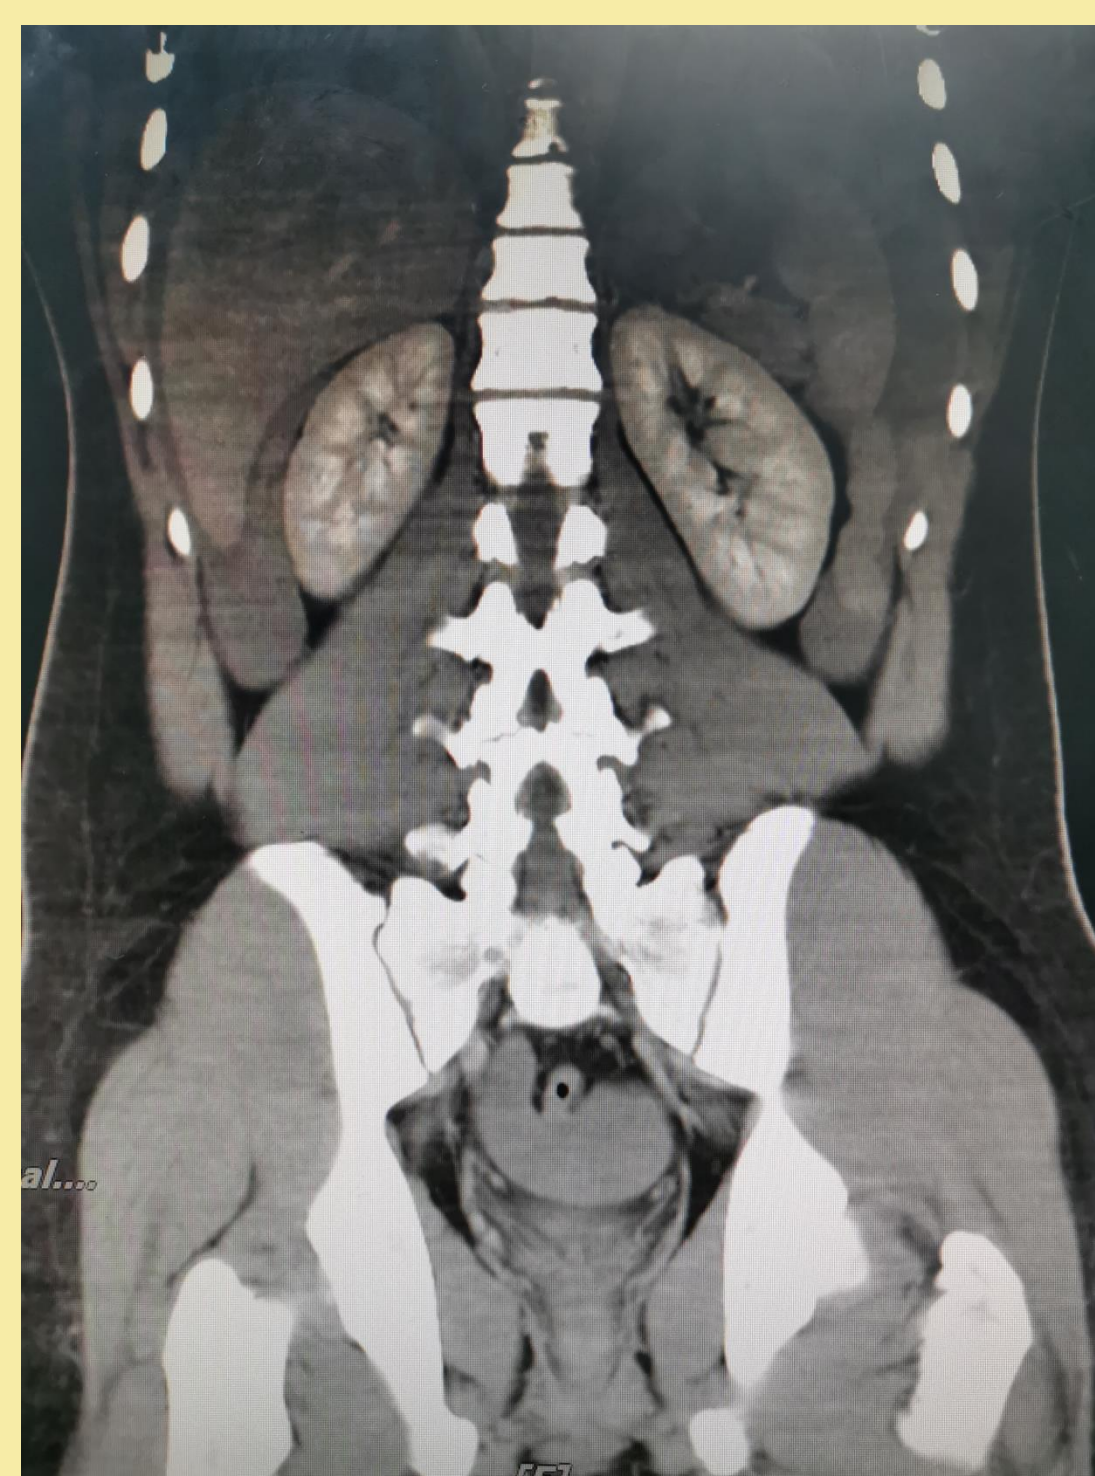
CT abdomen coronal view showed hemoperitoneum
